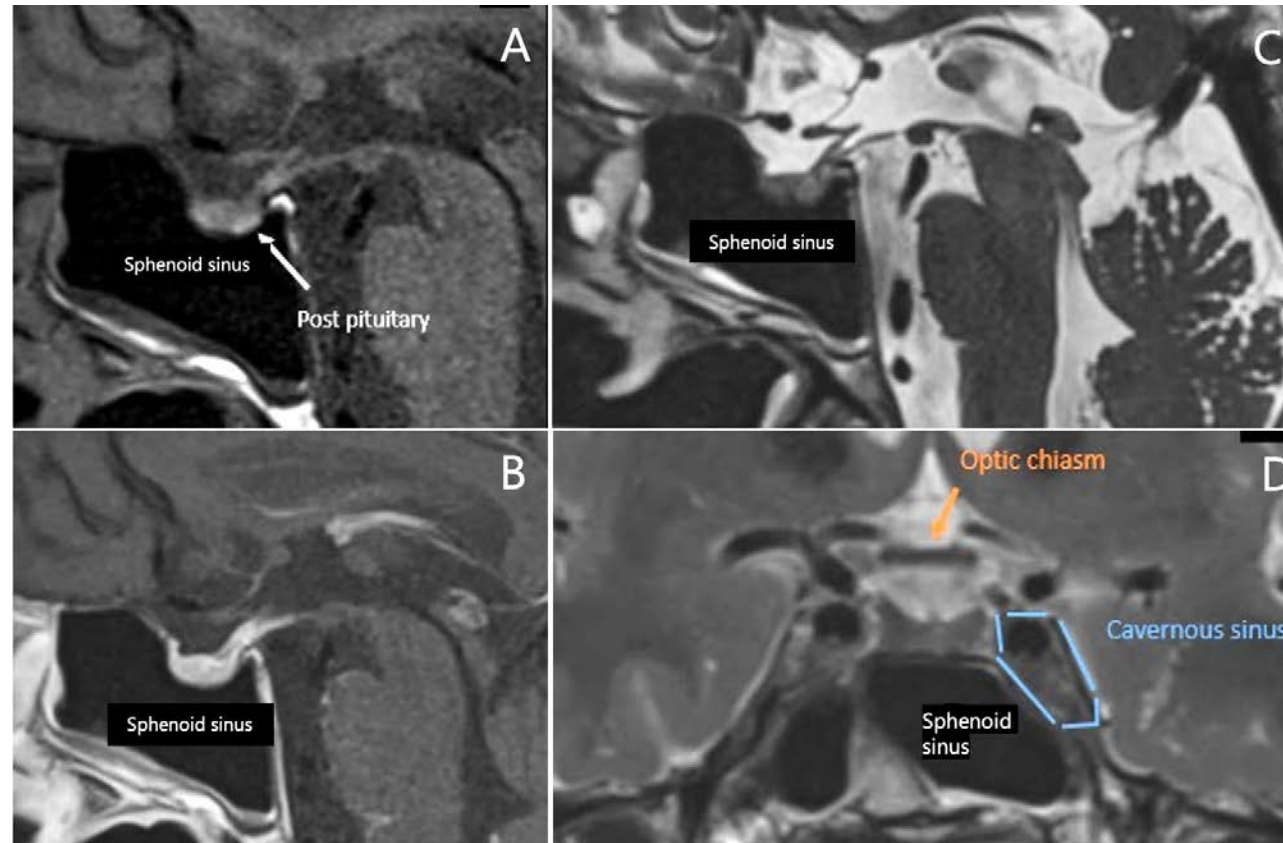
Sagittal T1W MR image (A) shows normal high signal of the post-hypophysis. Corresponding contrast-enhanced T1W (B) image demonstrates normal homogenous enhancement of the gland and pituitary stalk. Sagittal (C) and coronal (D) T2W images show the anatomical position of pituitary fossa just above the sphenoid sinus, in between the paired cavernous sinuses and below the optic chiasm.
